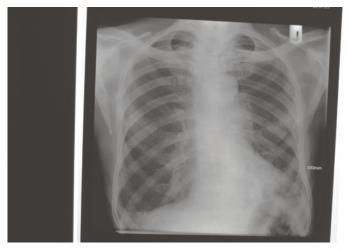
Chest radiograph showing patchy opacities in both lung bases worse on the left. Note flattening of the right hemi diaphragm
